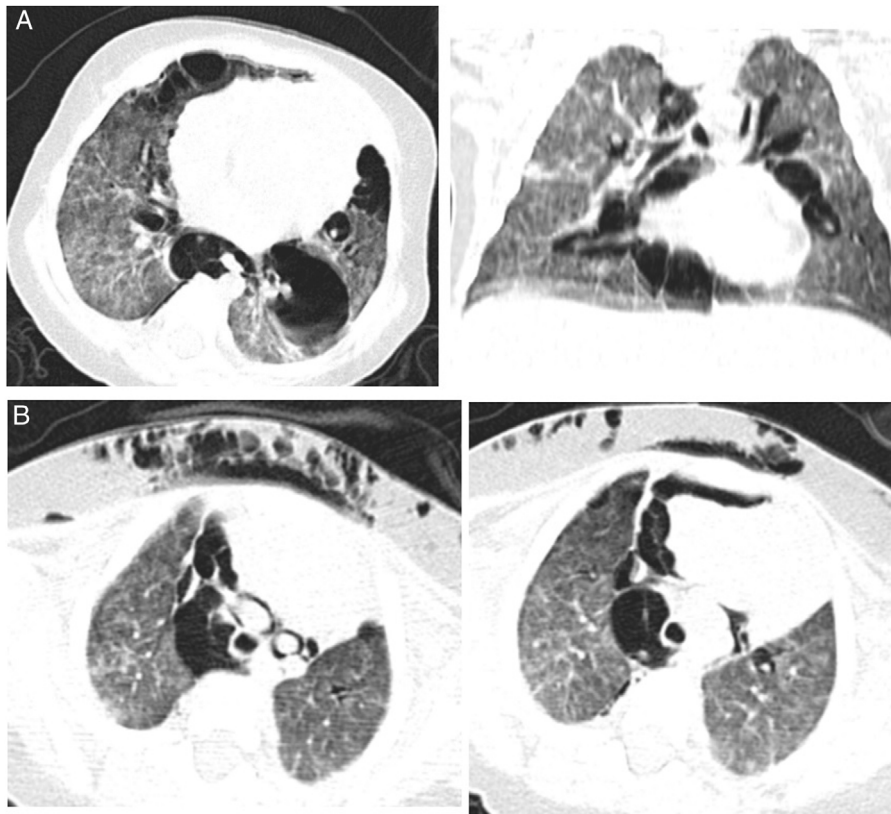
(A) Computed tomography scan in axial and coronal planes showed bilateral diffuse interstitial infiltration in the lungs and subpleural thin-walled cysts. (B) Pneumomediastinum and subcutaneous.
